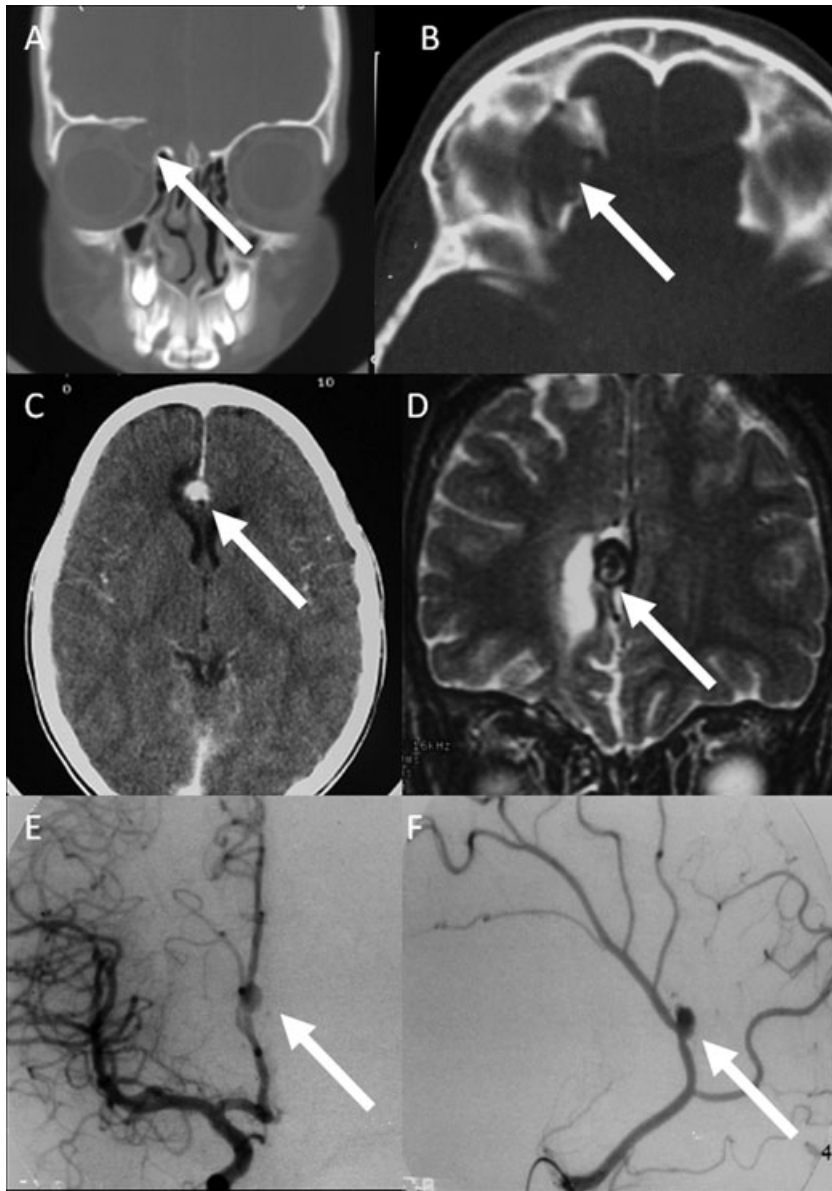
Coronal (A), axial (B), and contrast enhanced axial (D) CT images, coronal T2-weighted MRI (D) and AP and lateral digital subtraction angiography (DSA) (E, F) images of a 6-year-old boy who fell down while running with a pencil in his hand. The pencil had penetrated the right orbital roof (arrow) resulting in a bony defect (A, B) as well as a small brain defect within the right paramedian frontal lobe (C). Contrast enhanced CT showed a posttraumatic contrast enhancing right pericallosal artery aneurysm (arrows). The aneurysm was confirmed by the coronal T2-weighted MRI (hypointense flow void) and DSA (E, F).
